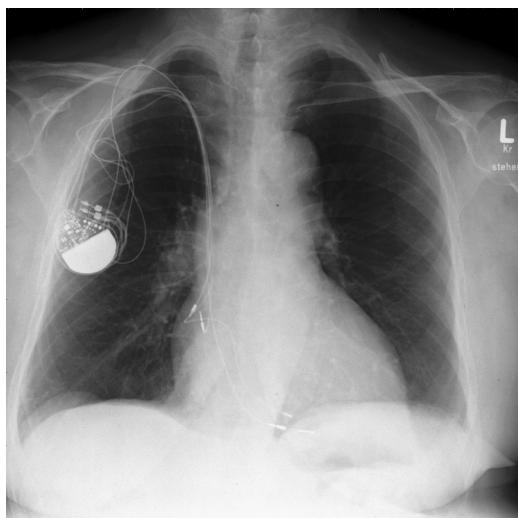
Posteroanterior chest radiograph of the patient at discharge.
